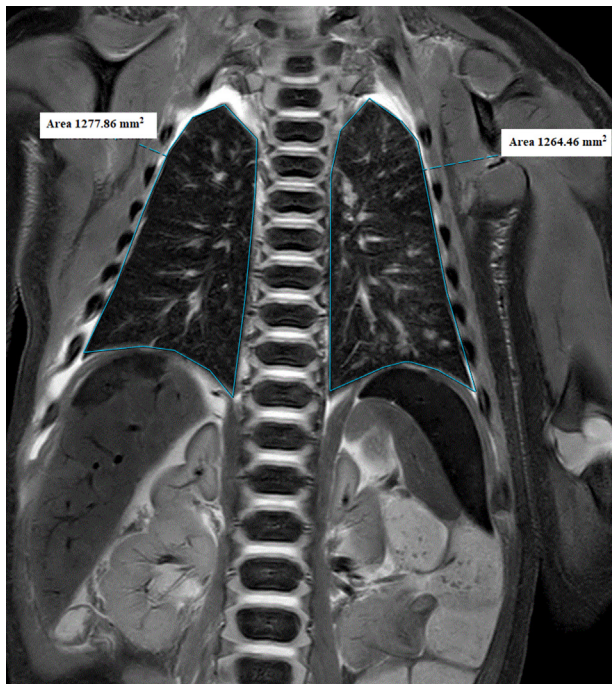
Coronal T2-weighted image with example of lung volume calculation. The lung area of this section is calculated for both lungs. Lung volume is calculated as the sum of the total area of all sections multiplied by section thickness.
